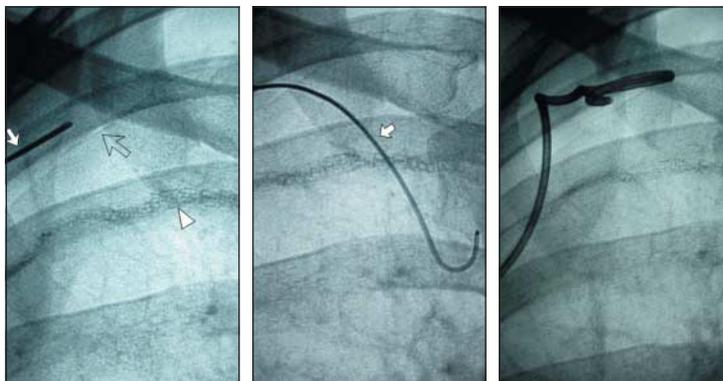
(left) Small pneumothorax post-pleurectomy at right apex (open arrow). Fluoroscopic guided needle puncture (white arrow) is being carried out. This unusual approach through the first intercostal space could damage subclavian vessels, which can be avoided by preliminary ultrasound examination of the needle path (arrowhead=suture material). (centre) Wire (arrow) is placed through the needle after aspiration of air. (right) Pigtail catheter coiled in pneumothorax and connected to underwater seal
